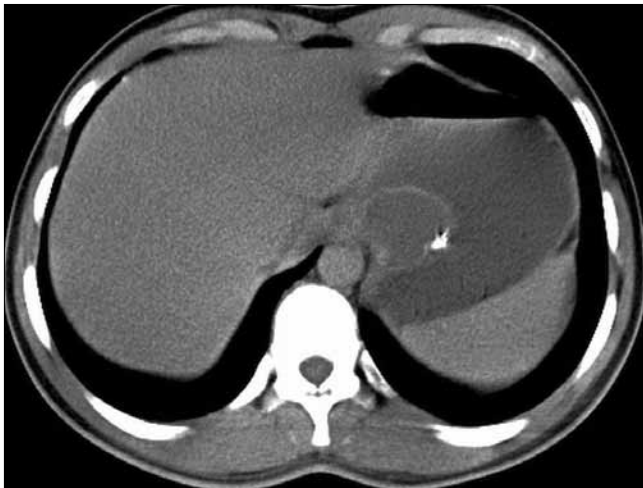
An axial CT image showing a cystic mass with a partially calcified wall attached to the posteromedial portion of the stomach.
